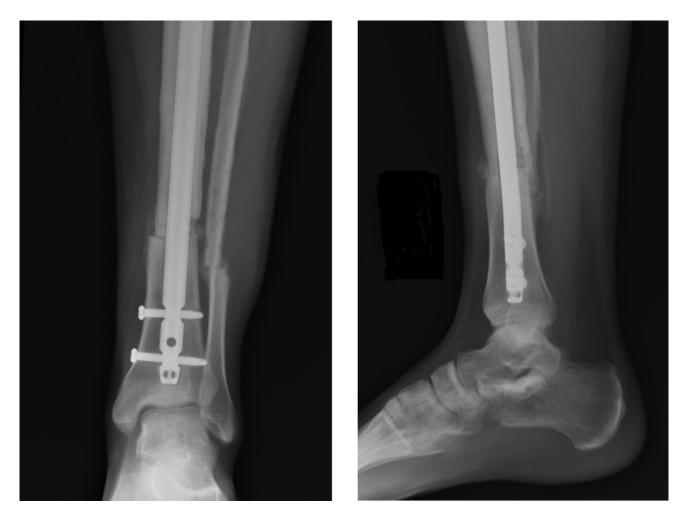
Anterior-posterior and lateral radiographs demonstrating callus formation of tibia after revision surgery.
